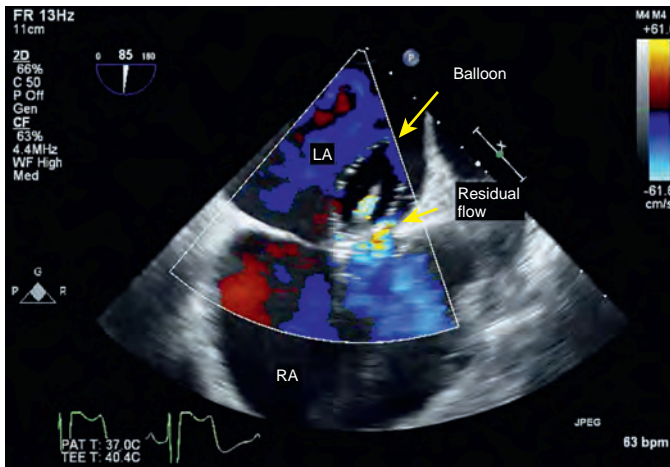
Midesophageal bicaval view with color-flow Doppler demonstrating persistent flow across the atrial septal defect despite balloon inflation. LA, Left atrium; RA, right atrium.
